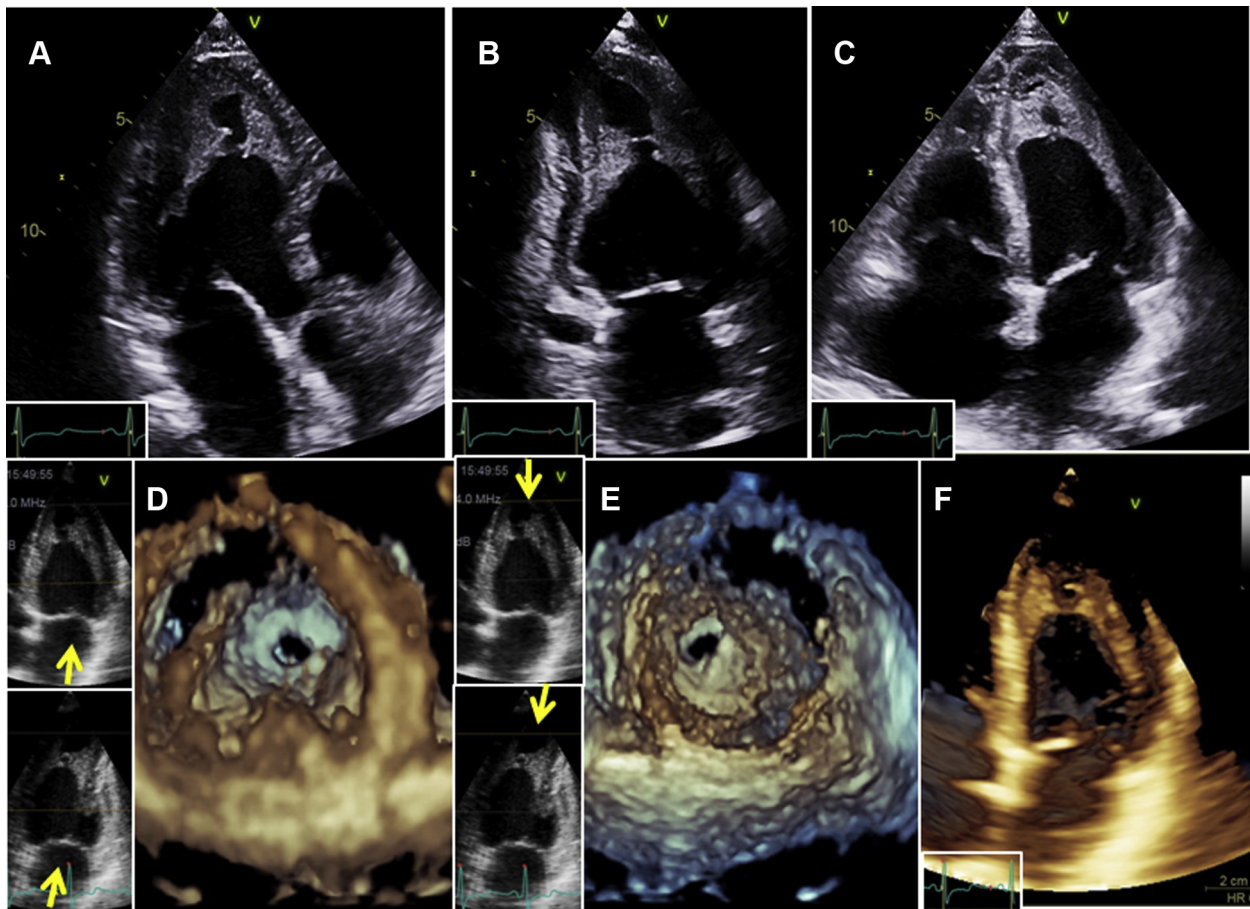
Standardized apical views of 2D-TTE (A, four-chamber view; B, two-chamber view; C, three-chamber view) in a patient with LE showing LV apical endocardial thickening and apical thrombus. Note the almost complete obliteration of the apex during systole providing the typical image of “kissing ventricle.” Three-dimensional TTE showing the en face view from the center of the LV cavity into the apex (D) and from the apical region into the midventricular region (E). The direction of the views is shown by the *yellow arrows*. (F) Three-dimensional TTE apical four-chamber view of LV showing a diffuse LV endocardial thickening with thrombus in the apex.
